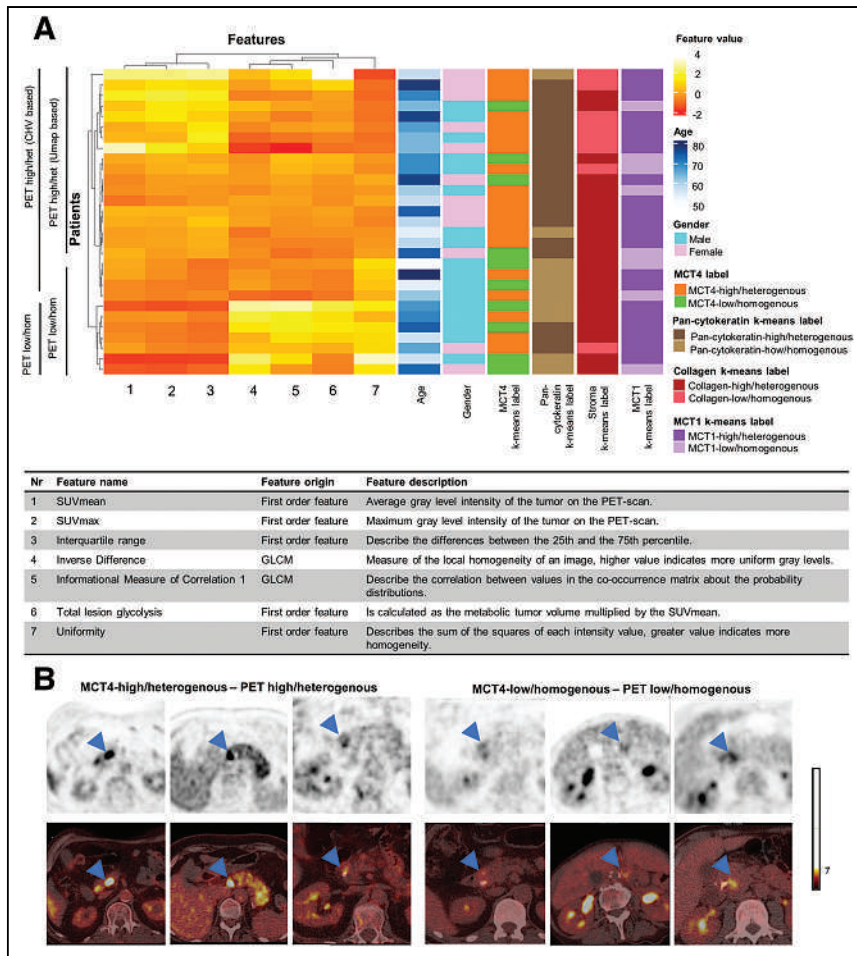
MCT4 expression profiles link to $[^{18}\text{F}]\text{FDG}$ PET uptake patterns. (A) Visualization of PET feature values of selected radiomics features using CHV. (B) Visualization of $[^{18}\text{F}]\text{FDG}$ uptake patterns (arrowheads) on representative examples of PET scans of MCT4-high/heterogeneous and MCT4-low/homogeneous. GLCM = gray level cooccurrence matrix; het = heterogeneous; hom = homogeneous.
